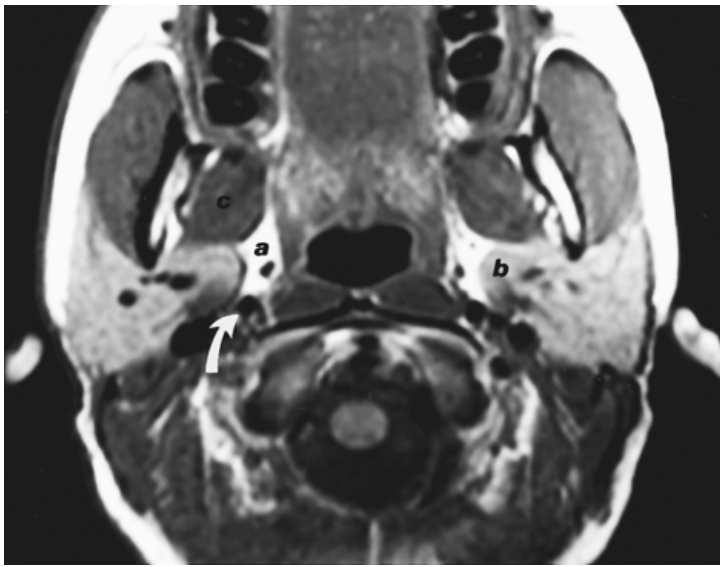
Normal anatomy. Axial T1-weighted sequence from a magnetic resonance imaging scan of the neck. (a) The parapharyngeal space is bright in signal intensity because it contains fat. (b) The deep portion of the parotid space and (c) the pterygoid muscle within the masticator space are directly adjacent to the parapharyngeal space. The curved arrow points to the right internal carotid artery within the carotid sheath.
